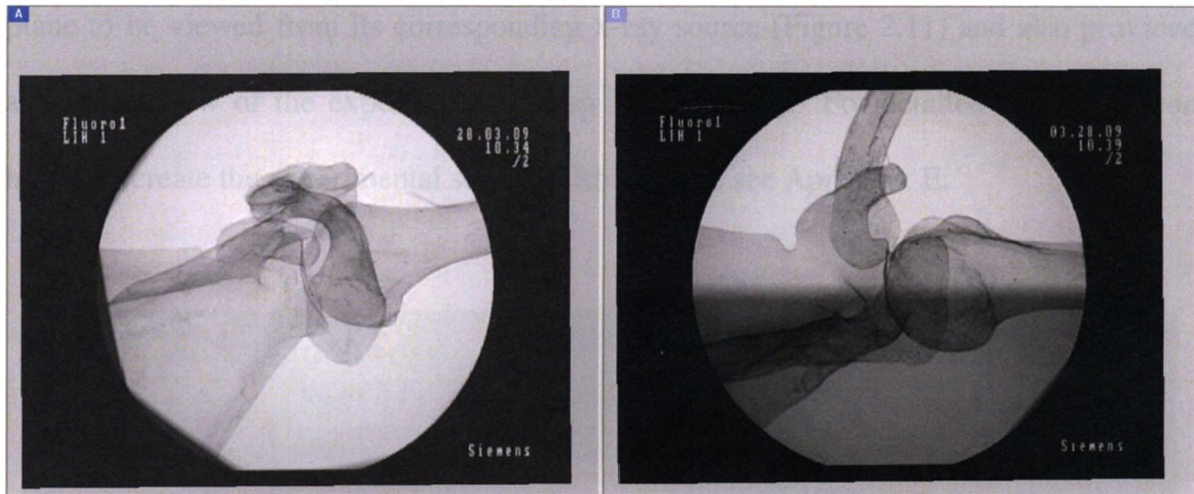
Two viewpoints from the two x-ray foci
